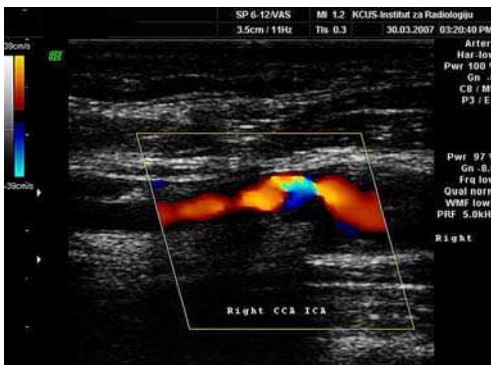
(a, b). Colour Doppler ultrasound (CD US) images showing stenosis of the initial part in the right internal carotid artery (RICA) and its increased spectral values.
